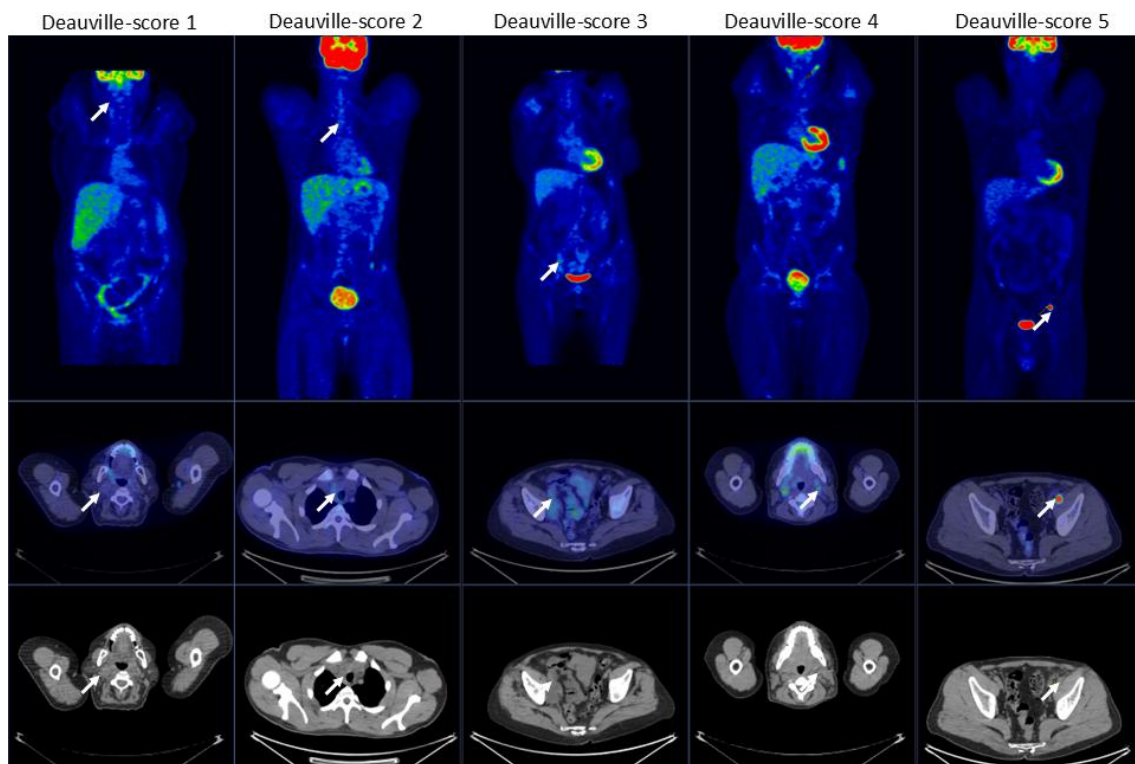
Demonstrative images of residual lymphoma lesion (arrows) uptake according to the Deauville-5-point-scale. Upper row: coronal FDG-PET images; Middle row: axial fused FDG-PET and CT images; Lower row: axial CT images. PET/CT data from the Semmelweis University, display is own work.
